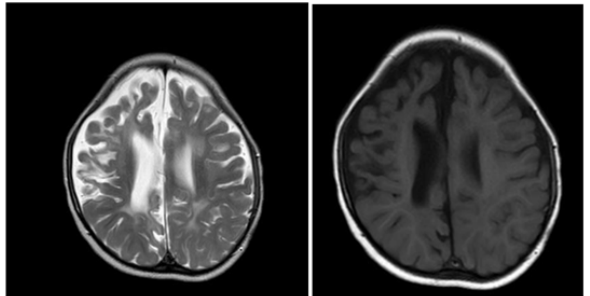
MRI Axial T2 and FLAIR images showing diffuse hyperintensities in periventricular and subcortical white matter predominantly in right fronto-parietal region with associated volume loss and prominent subarachnoid spaces suggest Hypoxic
